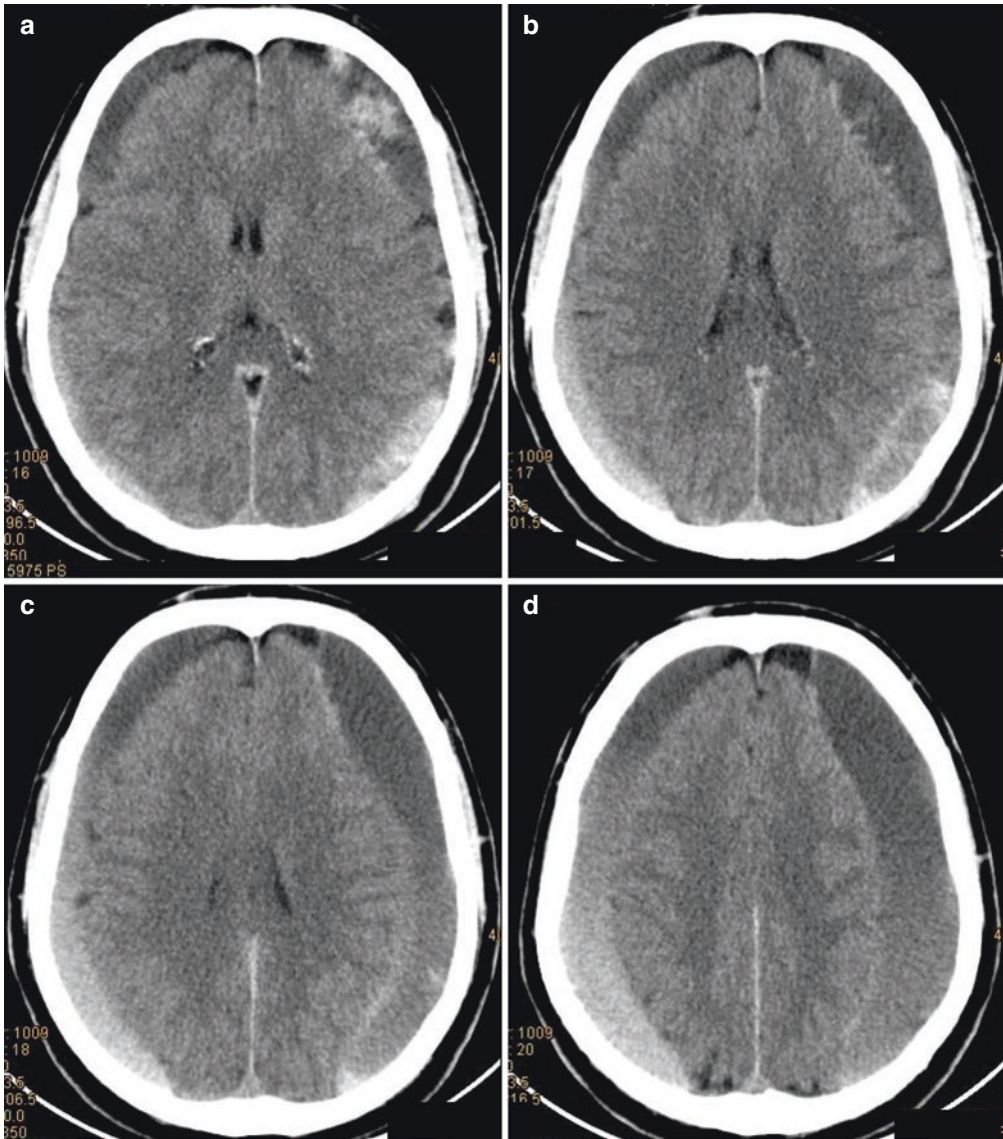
(a–d) CT scan. Subacute–chronic subdural hematomas: bilateral subdural collections composed of blood products in different stages deriving from repeated hemorrhages
